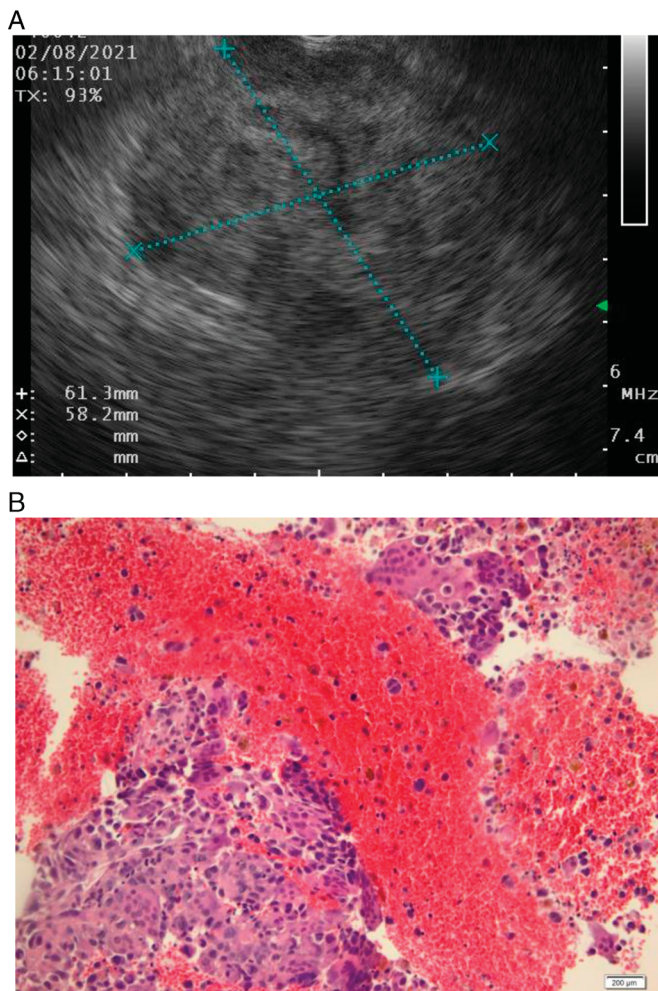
Pancreatic osteoclast-like giant cell carcinoma. EUS evaluation found a large inhomogeneous mass determining splenic vein thrombosis (A). EUS fine-needle biopsy was performed using a 22-gauge Acquire needle (Acquire™ Endoscopic Ultrasound Fine Needle Biopsy (FNB) Device, Boston Scientific corporation, Marlborough, Massachusetts, United States); the smears showed multiple giant cells with many clustered nuclei and prominent nucleoli, along with mononucleated and highly atypical tumor cells, consistent with osteoclastic-like giant cell pancreatic carcinoma. Courtesy of Cristiana Popp, MD, Department of Pathology, Colentina Clinical Hospital, Bucharest (B).
